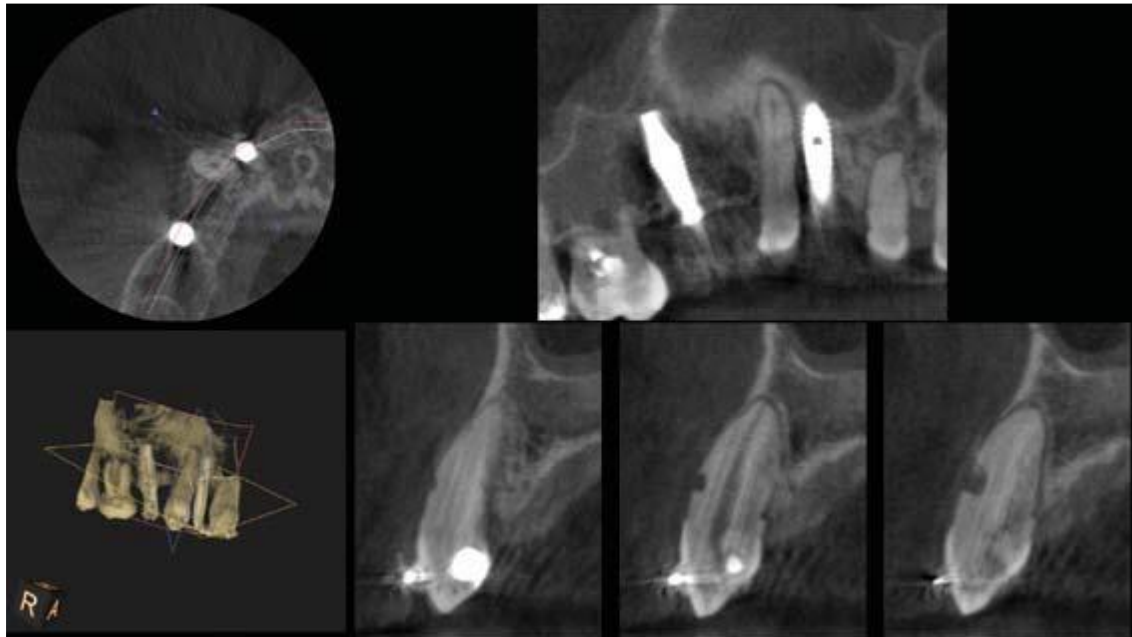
Cone-beam computed tomographic images show a tooth with external resorption communicating with the root canal.
